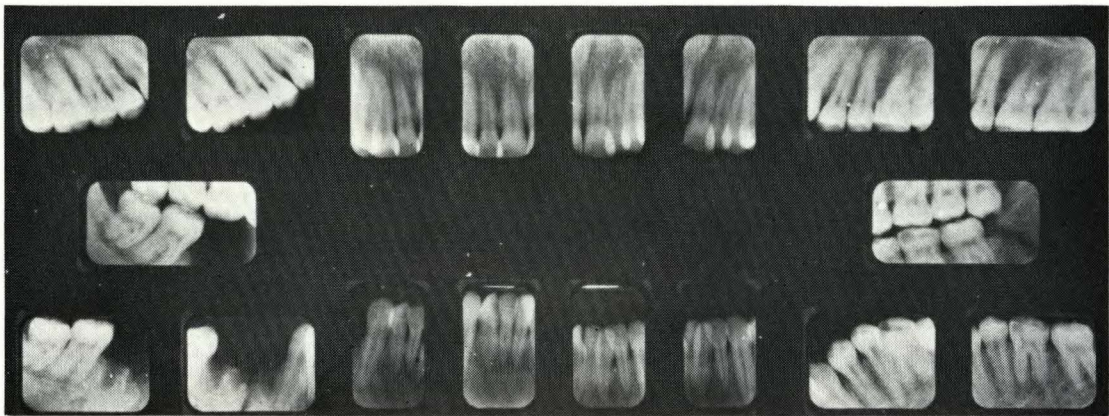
Full-mouth radiographs
